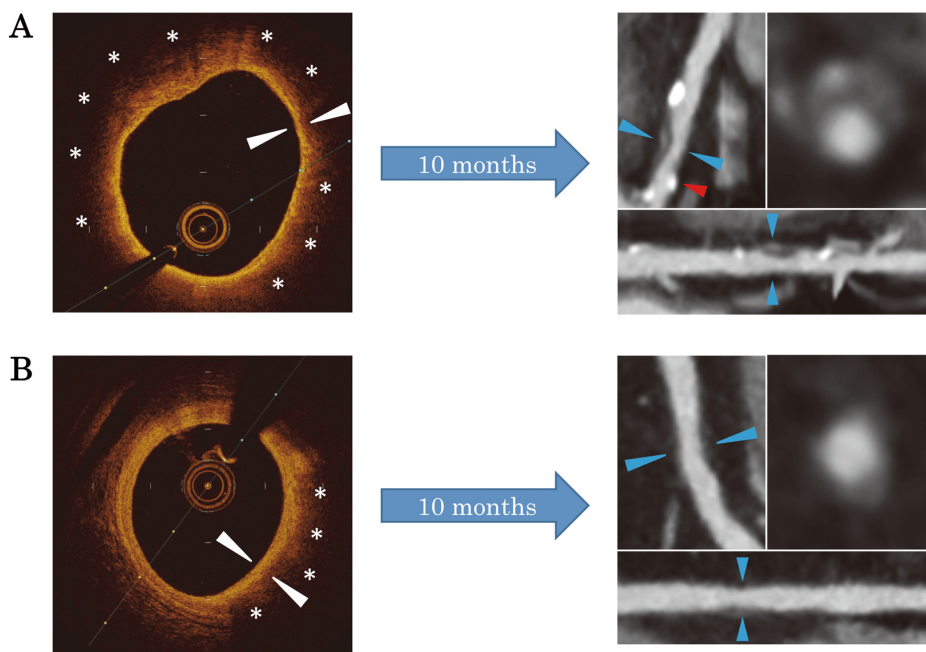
Representative images of baseline optical coherence tomography (OCT) and follow-up coronary computed tomography angiography (CCTA) findings. (A) Representative image of lipid-rich coronary plaque (LRCP) showing high-risk LRCP at follow-up. The OCT image shows a large lipid core with a thin fibrous cap. The maximum lipid arc is 320° (asterisks) and the minimum fibrous cap thickness was 50 μm (white arrowheads). The CCTA image of the same lesion shows high-risk plaque features (HRPFs) with positive remodeling (remodeling index 1.2), very low attenuation plaque (minimum CT value -2 HU), napkin-ring sign (blue arrowheads), and spotty calcification (red arrowhead). (B) Representative image showing low-risk LRCP at follow-up. The OCT image shows a maximum lipid arc of 100° (asterisks) and a minimum fibrous cap thickness of 120 μm. The CCTA image at follow-up showed no HRPF (remodeling index 1.04 and minimum CT value 45 HU).
